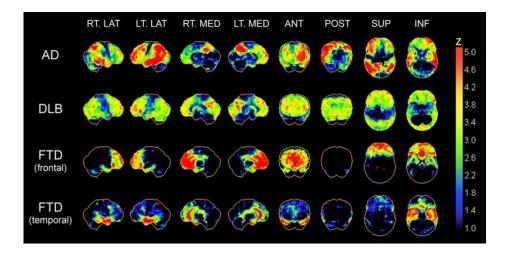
Typical regional cerebral 18F- FDG hypo metabolism patterns in AD, DLB, and frontal and temporal FTD (Nicolass I. Bohnen, January 2012)
